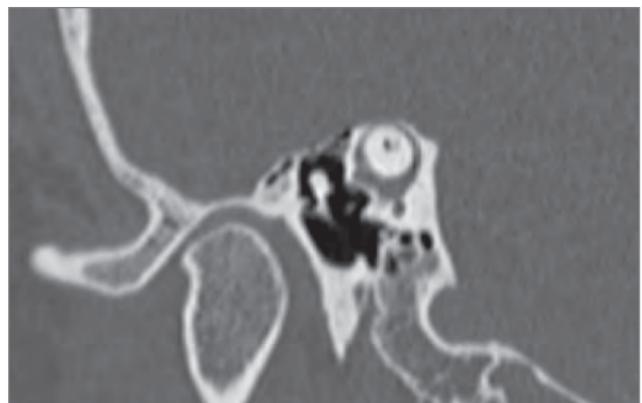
CT scan of superior semicircular canal dehiscence. This is a parasagittal non-contrast CT of the left superior canal in the plane of the canal. An open dehiscence can be seen in the top of the arch of the canal.
